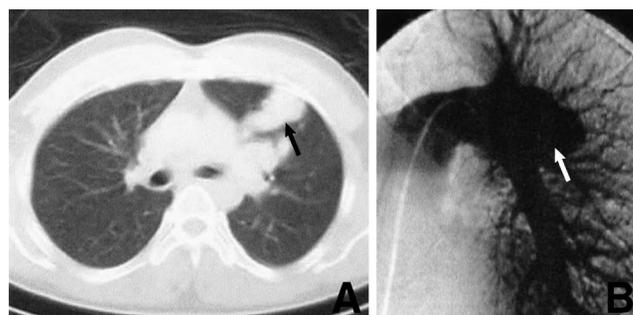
Chest computed tomography scan with contrast medium (A) and left pulmonary artery angiogram (B) revealing an abnormally dilated vessel in the upper lobe of the left lung (arrows).
